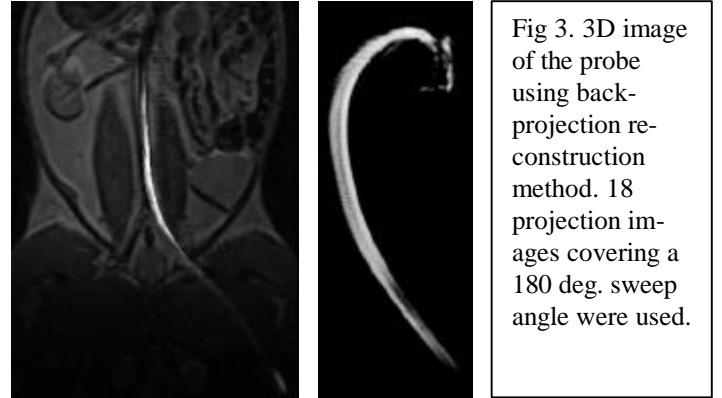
3D model of the probe with roadmap MRI image
